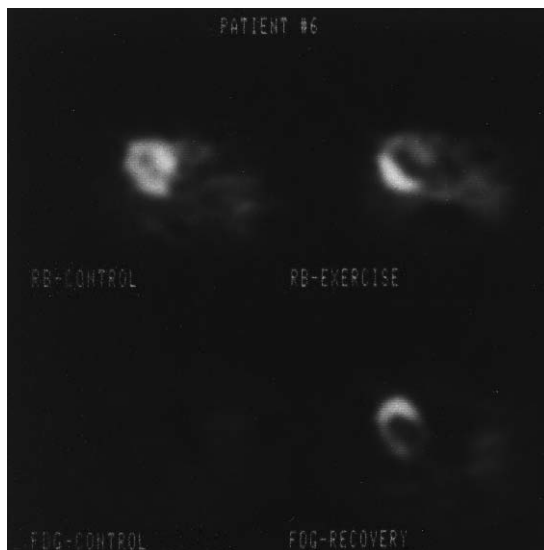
PET images of the chest of a patient with stable angina. In each image the left ventricle free wall is in the 6 to 10 o'clock position, the anterior wall and septum are in the 10 to 3 o'clock position, and the remaining open area is the plane of the mitral valve. Myocardial uptake of rubidium-82 (RB) at rest (top left) is homogeneous, while during exercise (top right), cation uptake is severely reduced in the anterior wall. When FDG was injected at rest (bottom left) after overnight fasting, myocardial tracer uptake was very low, the heart profile being barely detectable. In this patient FDG was also injected during recovery from the stress test when all signs of ischaemia had disappeared. Under these conditions (bottom right) the region of previous ischaemia was clearly identifiable, tracer uptake in the anterior wall being 1.75 times higher than that in non-ischaemic myocardium.
